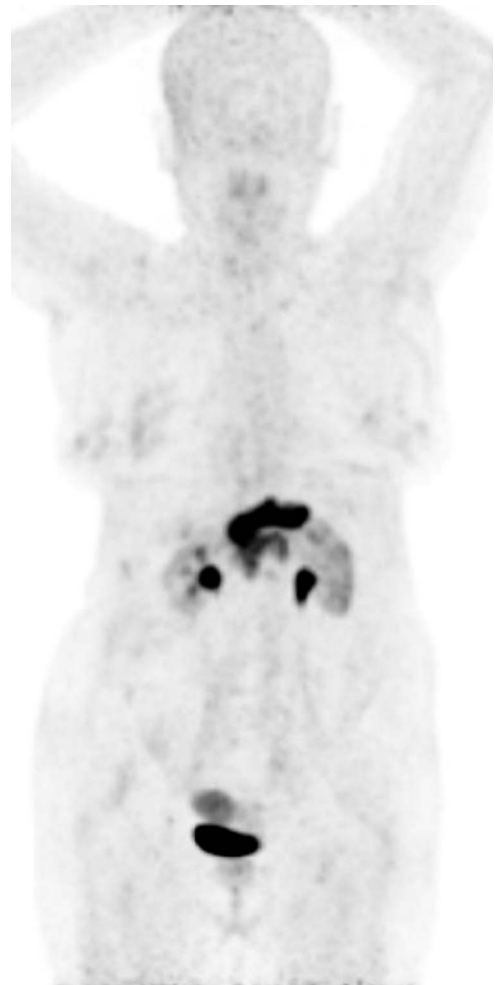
A 69-year-old woman with recurrent cholangiocarcinoma underwent ^{68}Ga -FAPI PET/CT. She could not perform ^{18}F -FDG because of uncontrollable diabetic hyperglycemia. The images revealed an intensely FAPI-avid ($\text{SUV}_{\text{max}}, 24.5$) soft tissue mass in the Whipple surgical bed along with several mildly FAPI-avid small peripancreatic lymph nodes and adjacent peritoneal nodules. A ^{68}Ga -FAPI-avid ($\text{SUV}_{\text{max}} = 9.3$) myoma was also detected in the uterus.
